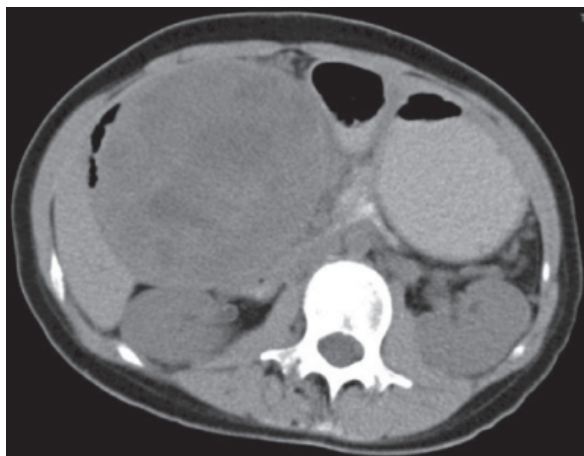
The abdominal CT scan showing a huge, well-defined arterial enhancing, mixed cystic-solid mass with internal calcification at the head of pancreas, measuring about $10 \times 9 \times 14.2 \text{ cm}^3$.
